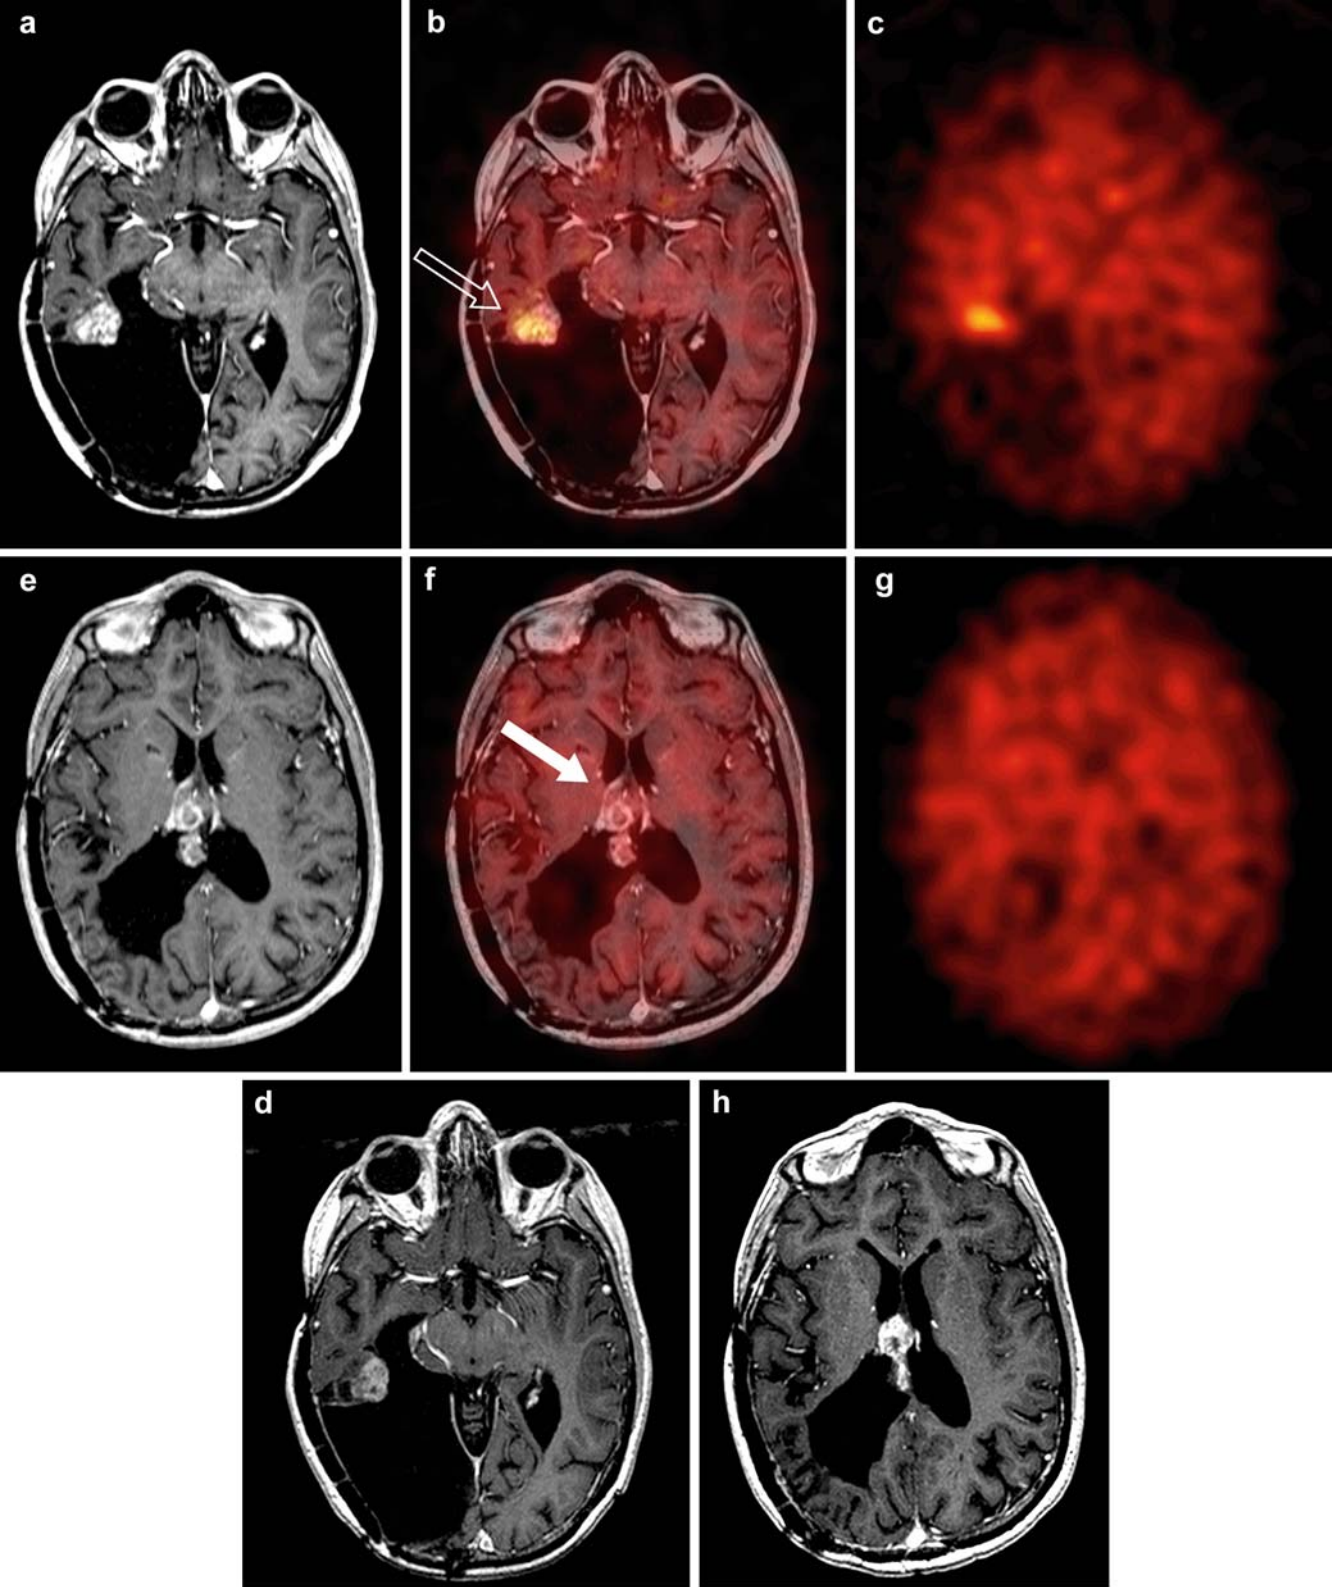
A 26-year-old female patient presented 4 years after surgery and radiochemotherapy with an ependymoma grade III (patient no. 21). The T1-weighted MR image (a, e) shows a suspicious enhancing lesion in the region of the known tumour, as well as the development of a new enhancing lesion ventral to the resection defect. SPECT (c) and fused image (b) demonstrate a high ¹²³I-MT uptake in the new tumour lesion (empty arrow), but show no tracer accumulation in the pre-treated tumour (e, f, g) (solid arrow). Based on these findings, the IMT-accumulating lesion was treated by stereotactic radiation therapy. Control MRI 6 months later showed no change in the IMT non-accumulating lesion (h) and a size reduction of the irradiated tumour (d)
